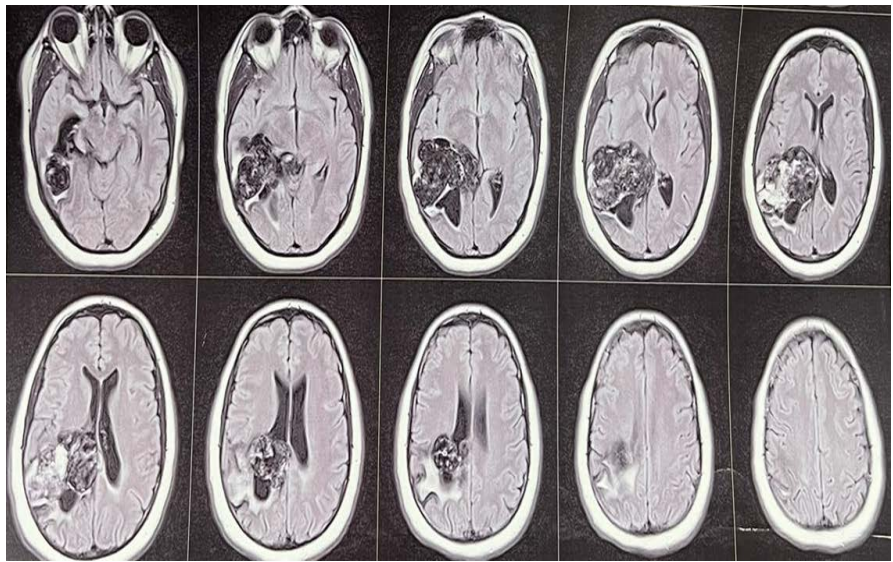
At up, a FLAIR-weighted image showing a heterogeneous mass with invasion of the right lateral ventricle atrium and adjacent edema.
